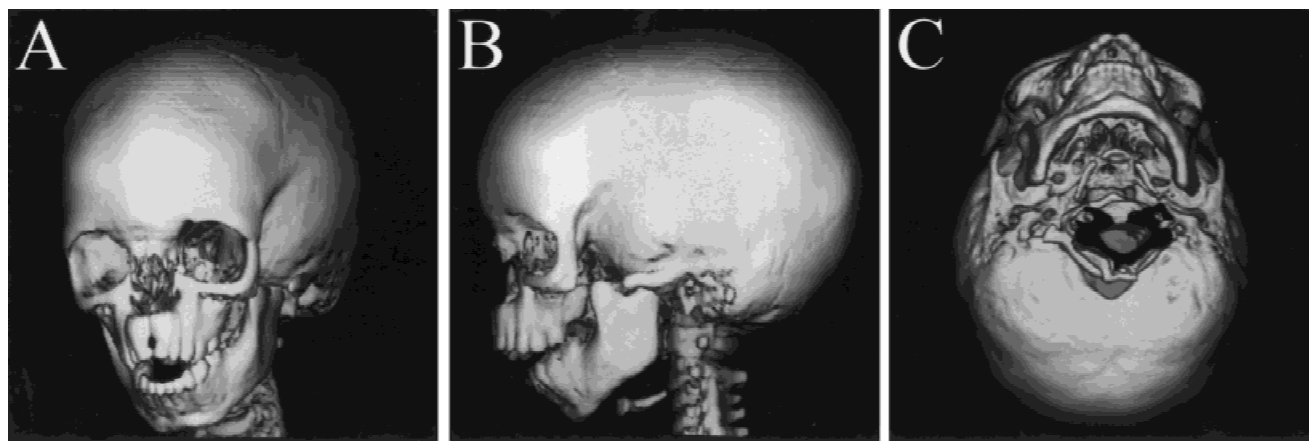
Shown are the three-dimensional CT scans at age 4 years: Left three-fourths view shows absent nasal bones, orbital hypertelorism, absent zygomatic arches, and midline maxillary cleft (A). Lateral view demonstrates micrognathia with condylar hypoplasia, anterior open bite, and absence of zygomatic arches (B). Inferior cranial base view demonstrates the absence of the zygomatic portions of the zygomatic arches with preservation of the temporal component as well as a large incisive foramen (C).
